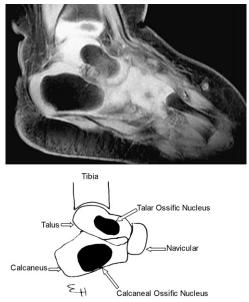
Sagittal plane MRI of the foot of an 18-month-old girl shows the appearance of the primary ossification centers of the talus and the calcaneus as they relate to the cartilage anlagen. The ossification centers are drawn in relation to the primary cartilage anlagen.
